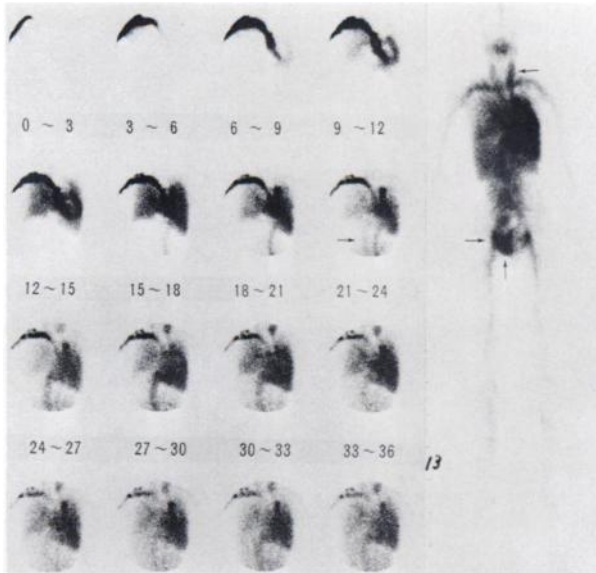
Anterior radionuclide angiograms and whole body scintigram in vivo labeled Tc-99m red blood cells. There is left-sided deviation of cardiac pool and early filling of the inferior vena cava (arrow). Filling defect at the inferior portion in the right atrium (arrow) is filled by blood from the inferior vena cava, considered to be laminar blood flow. An area of increased activity (venous phase) of unknown cause is seen in left neck (arrow). Whole-body scintigram shows abnormal blood pool in left neck and right pelvis (arrow).
